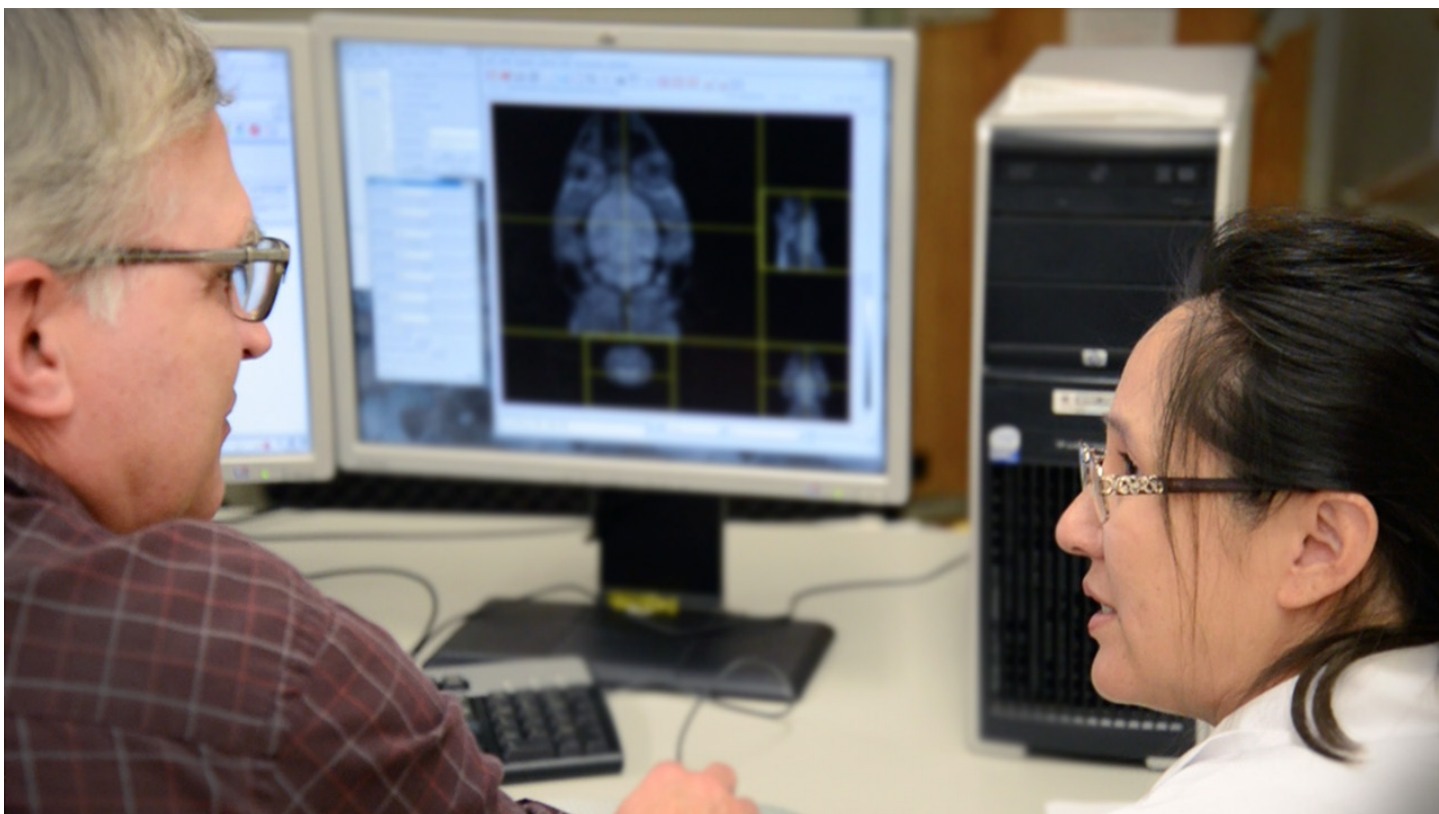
As with MRI laboratories, facilities using PET must adhere to regulations regarding safety and best practices for optimum efficiency in the facility. Instruments like Cubresa's NuPET imaging system can typically be operated from the same workstation area that already exists for the MRI technicians.
